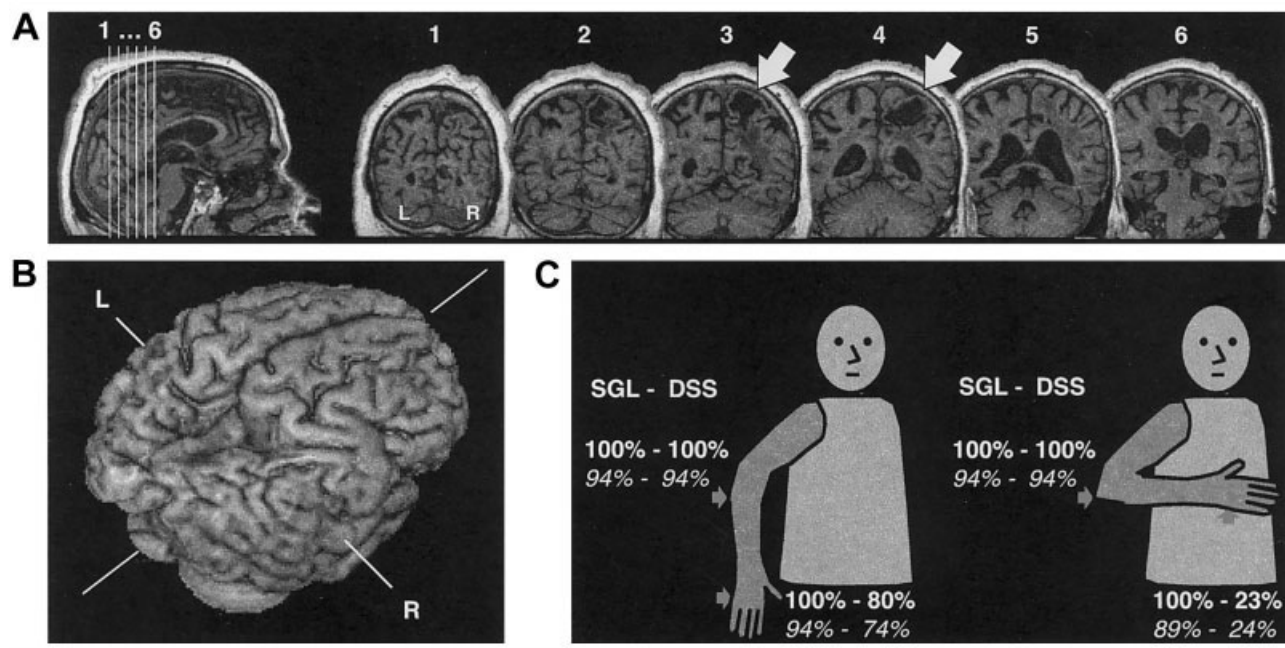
(A) T1-weighted magnetic resonance imaging (MRI) scan of the brain in our patient showing a chronic lesion in right parietal lobe (white arrows), extending in white matter. Only slight white matter disease was visible in the posterior left periventricular region, and the patient had no clinical left hemispheric symptoms. (B) Three-dimensional reconstruction of MRI showing the damaged cortical area. (C) Experimental testing of tactile extinction on the intact right hand was performed with the hand placed to the right or left of the trunk's midline (stimulation on the ulnar edge of the hand, elbow, both, or none), with eye closed, in a similar way both outside (percentage correct detection in boldface) and inside (percentage correct detection in italics) the scanner.
